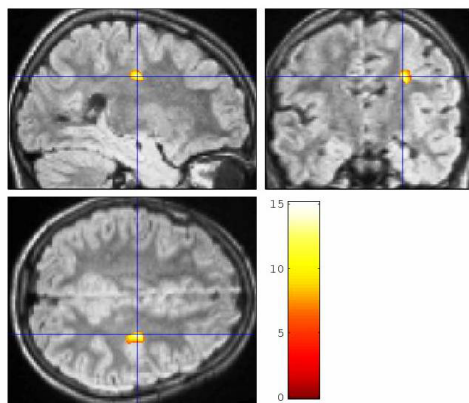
Child with cryptogenic IFE in whom VBM detected an abnormality in the right frontal lobe. Ictal EEG and SPECT localized to the right frontal region. Subsequent review of original MRI has confirmed that the area detected by VBM represents subtle FCD missed on original visual inspection.
